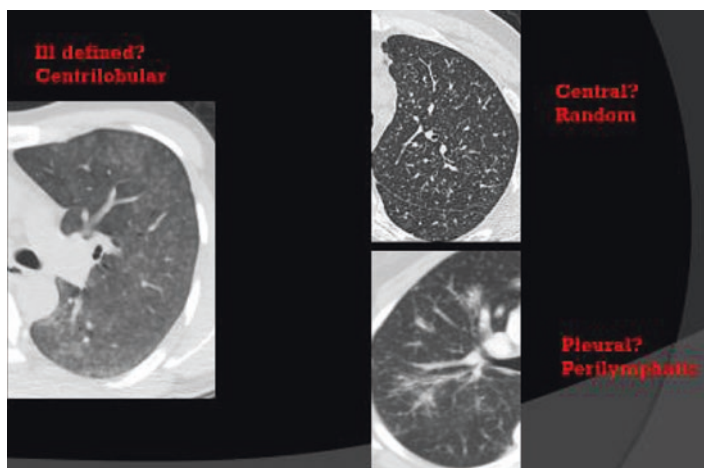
Differentiation of multiple pulmonary nodules on CT
